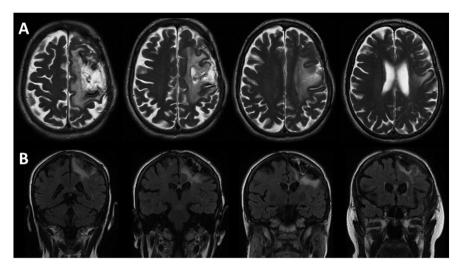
(A) Axial T2- and (B) coronal FLAIR-weighted MRI sequences disclose the remnants of the meningioma in the left frontal and parietal lobe, affecting mainly the precentral gyrus.
